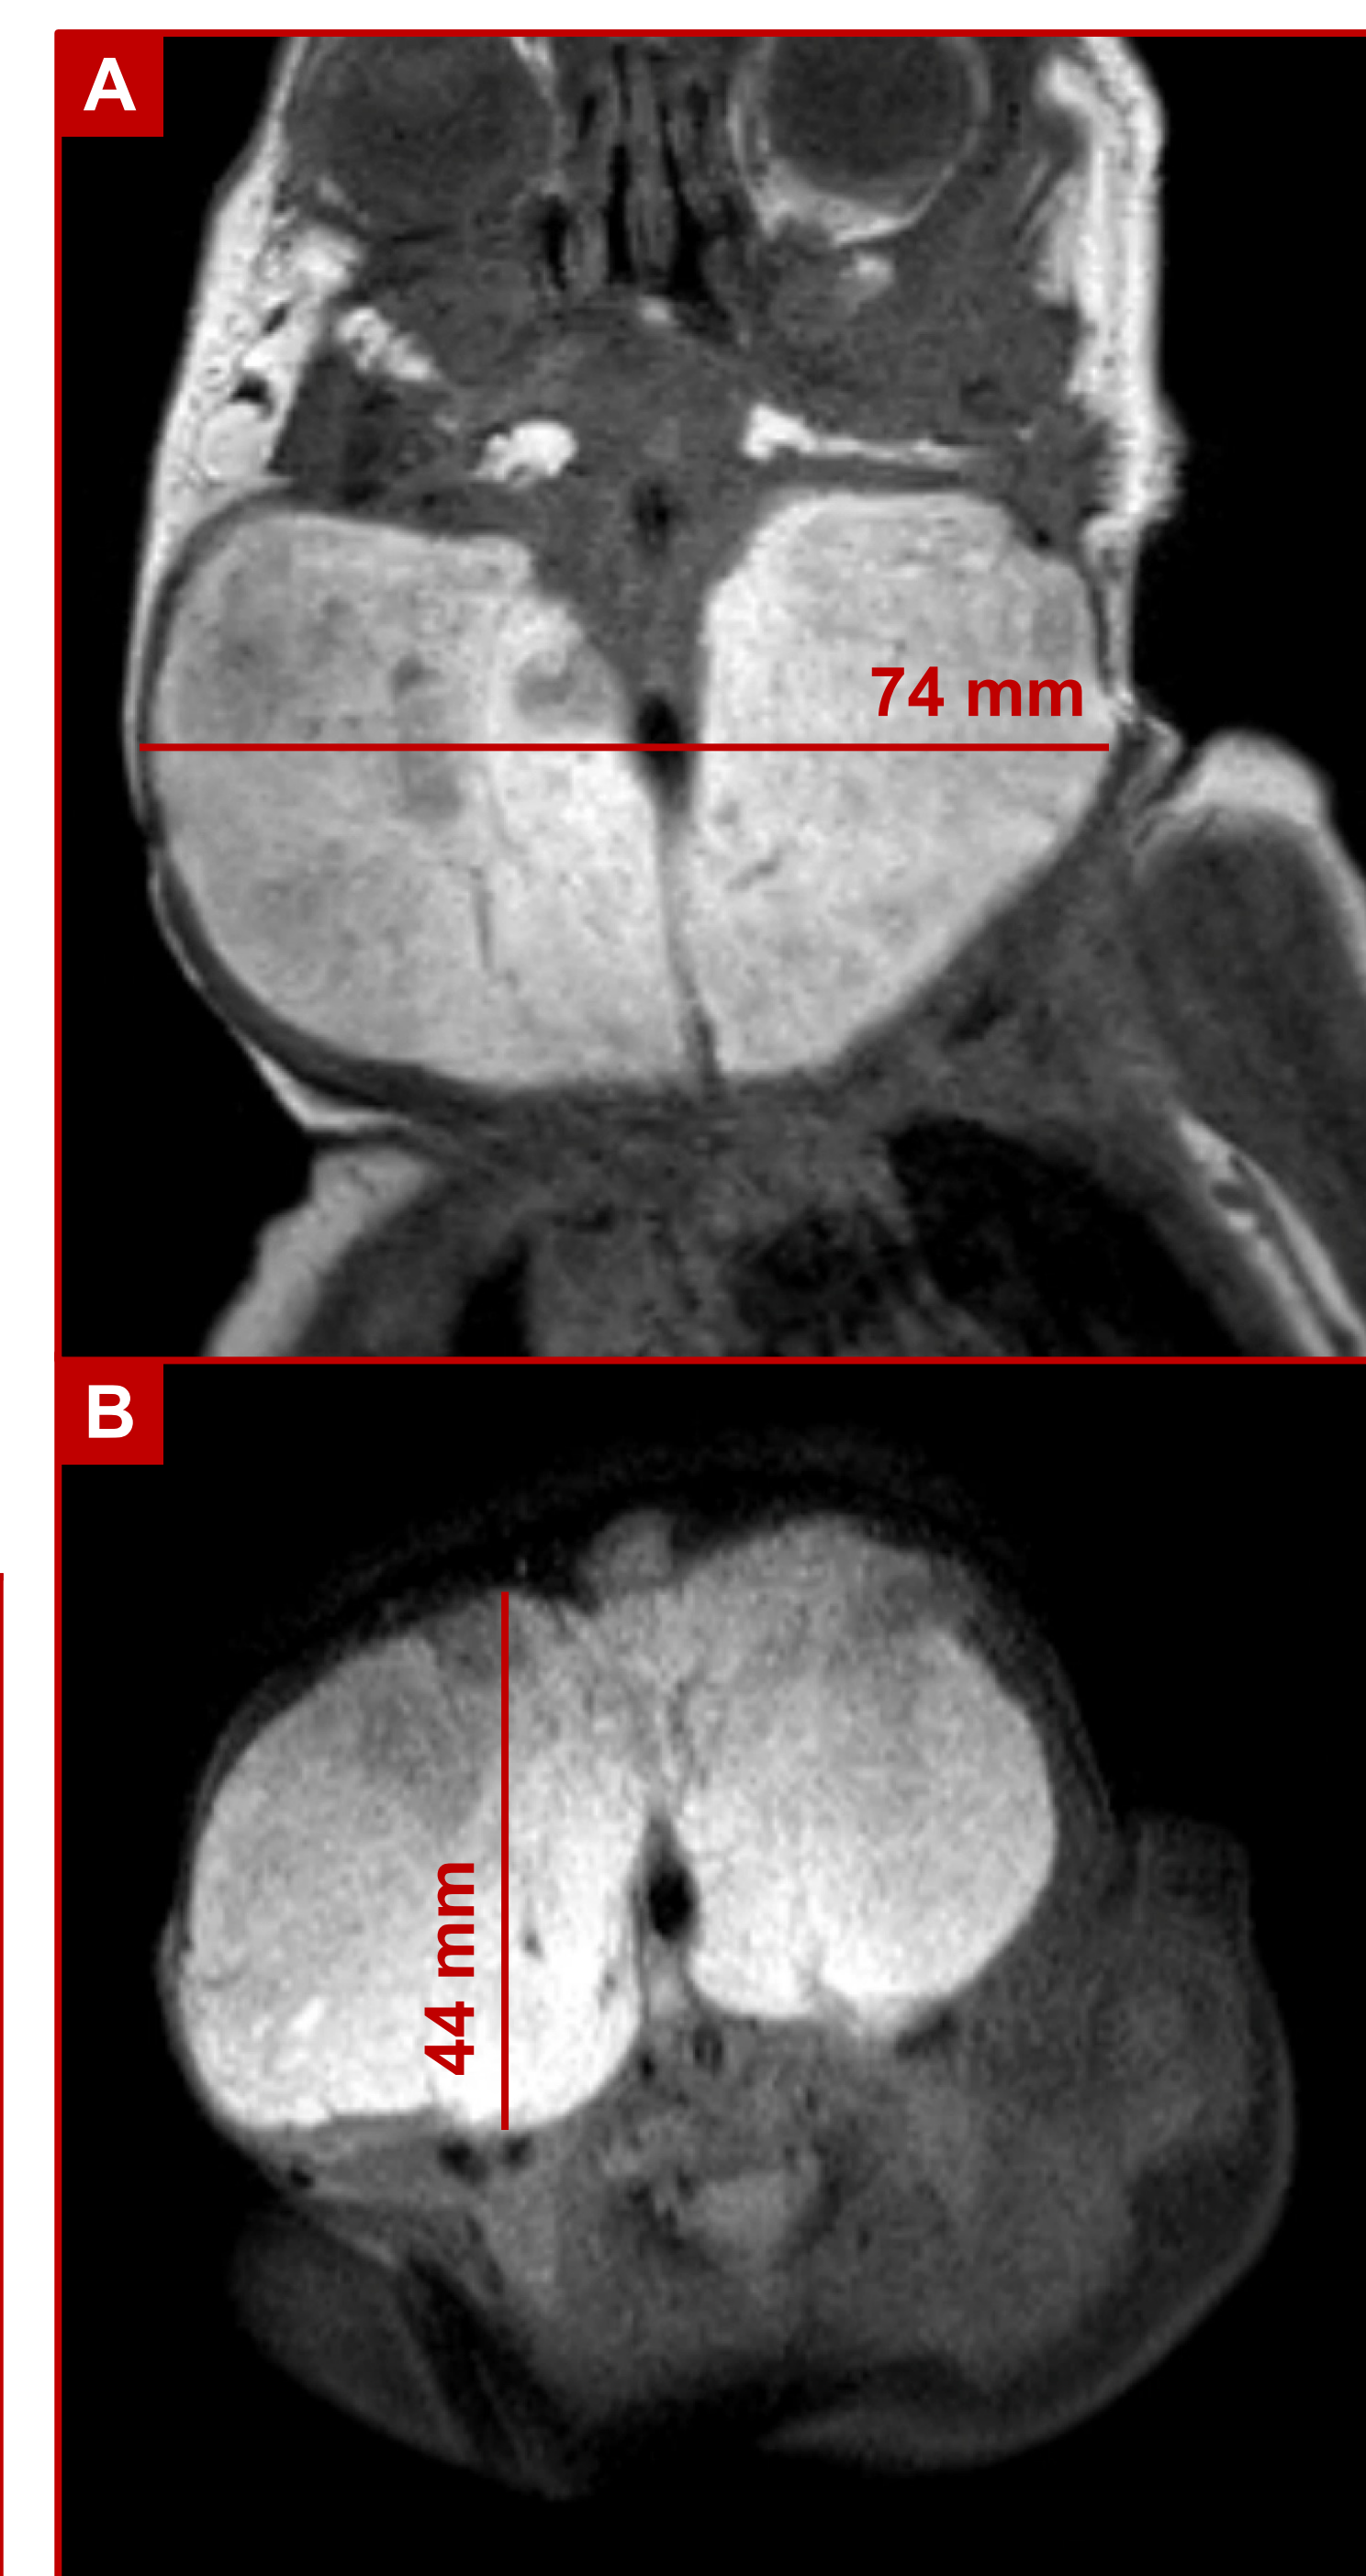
T1-weighted MRI in coronal (A) and axial (B) section; hyperintensity consistent with thyroid parenchyma
